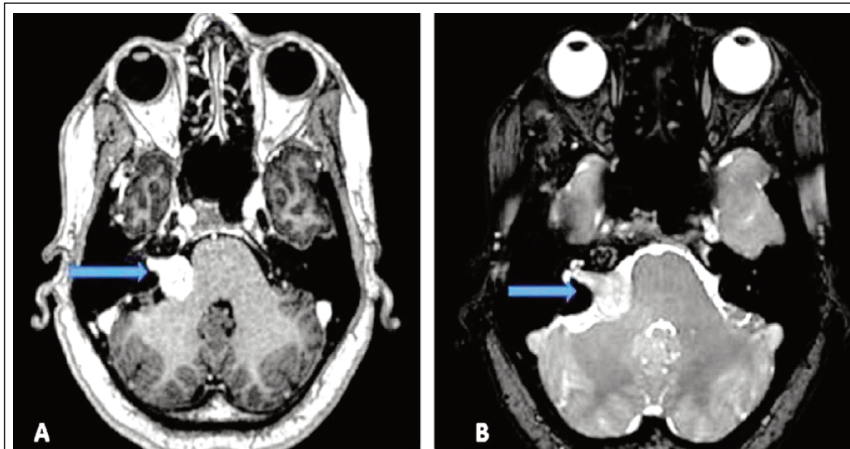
Right vestibular schwannoma. Magnetic resonance imaging (MRI) brain T1-weighted image (T1WI) contrast axial image (A) and Balanced Turbo Field Echo (BTFE) image (B) of a 45-year-old male showing right vestibular schwannoma with intracanalicular extension.
